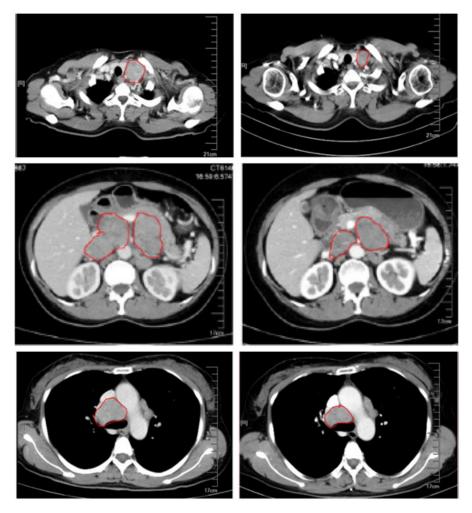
The enhanced CT comparison between the first admission(2018.06.17) and after 6 cycles of treatment with anlotinib (2019.05.31). The lymph nodes are significantly narrowed.
